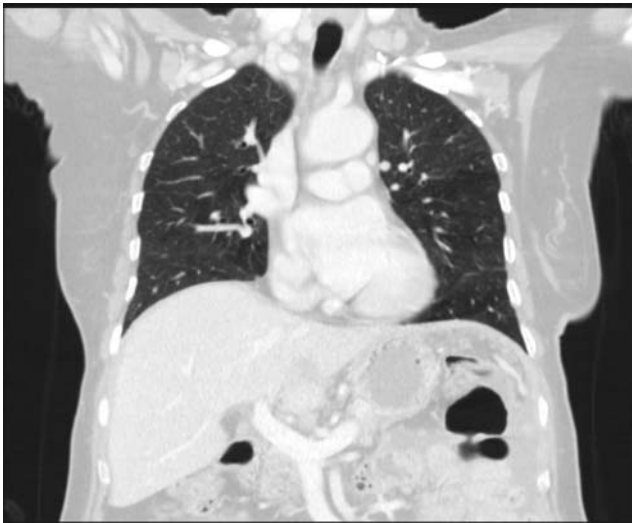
Coronal contrast-enhanced chest computed tomography scan shows no mediastinal lymph nodes, no evidence of metastatic disease, and no significant pulmonary finding except mild basal bronchial thickening.
